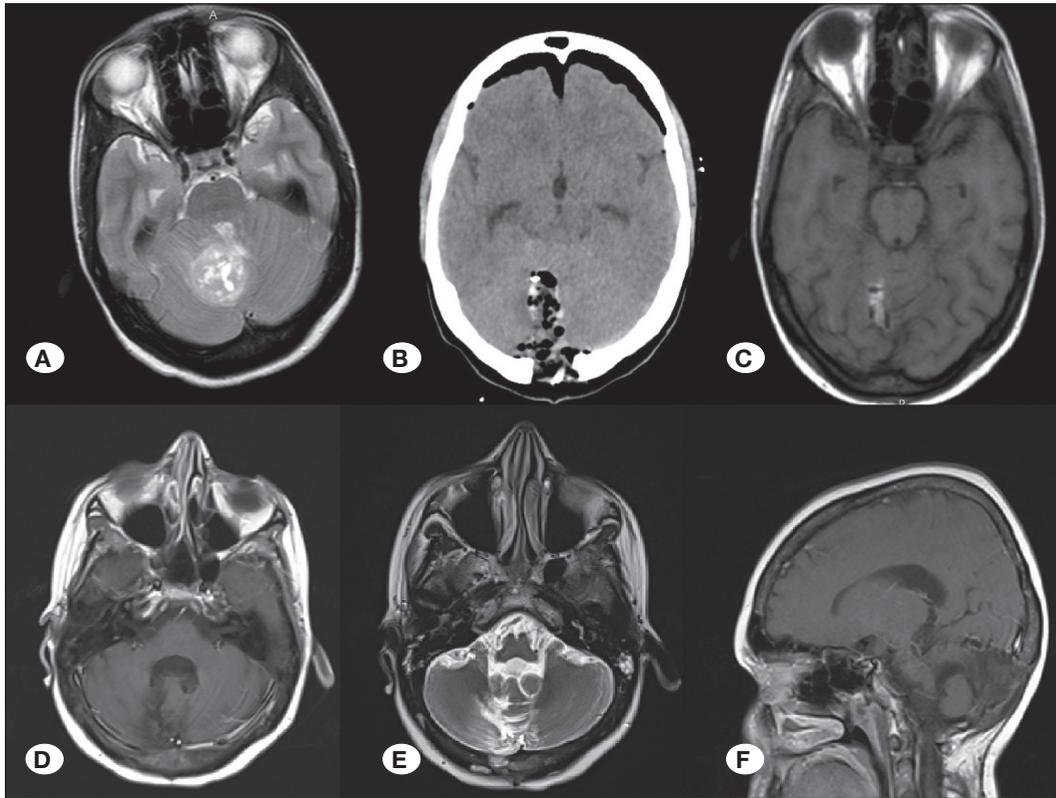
A) A midline cerebellar mass is visible in the axial section of T2W magnetic resonance imaging (MRI) scan. B) A postoperative axial computed tomography (CT) scan reveals that the mass has been totally excised. C) A postoperative first month follow-up axial T1W contrast enhanced MRI scan reveals that the mass has been totally excised. There is no recurrence or residual disease in the third year follow-up cranial MR scan (D: axial T1W contrast enhanced, E: axial T2W, F: sagittal T1W contrast enhanced).
